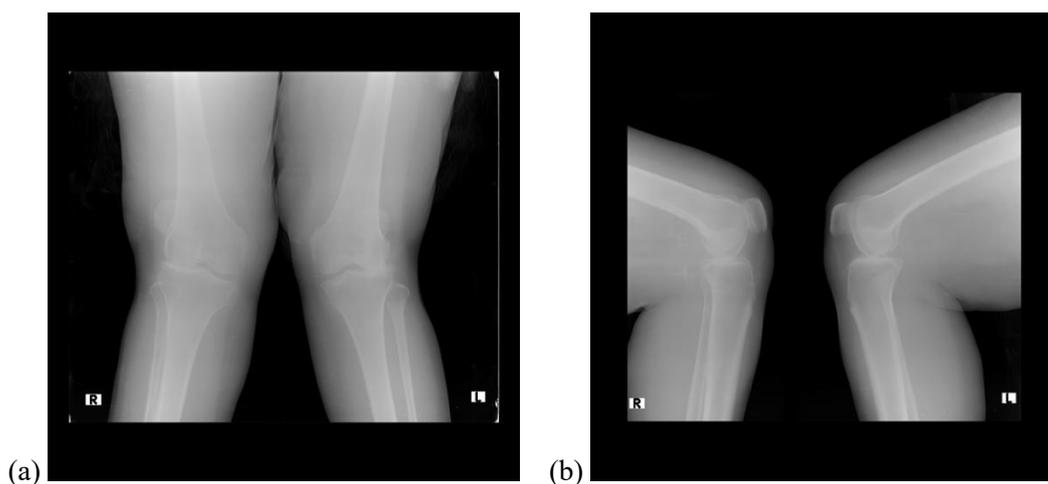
(a) AP and (b) lateral X-rays of bilateral knees showing grade IV osteoarthritis with bilateral genu valgum.
